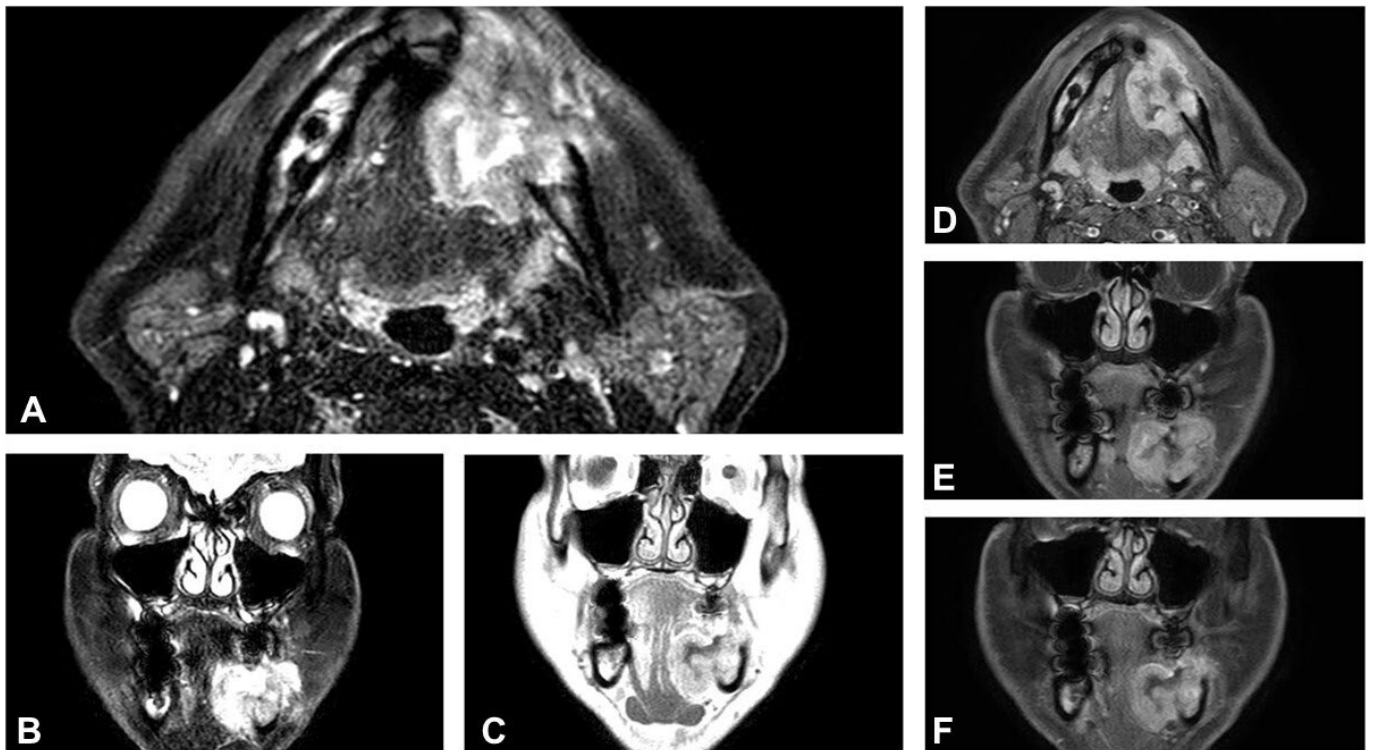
Magnetic resonance imaging demonstrating: (A) Infiltrative lesion in the left mandibular hemibody, with heterogeneous contrast enhancement and bone erosion. (B) Asymmetric involvement of the left side. (C) Heterogeneous enhancement of the left mandibular lesion and involvement of the inferior alveolar nerve canal, suggesting perineural spread. (D) Evident bone destruction on the left side and enhancement that reinforces the infiltrative character. (E) Deep infiltration of the sublingual space and adjacent tissues and asymmetry between the cervical compartments. (F) Infiltration of the sublingual space and enlarged lymph nodes at level I B are observed.
